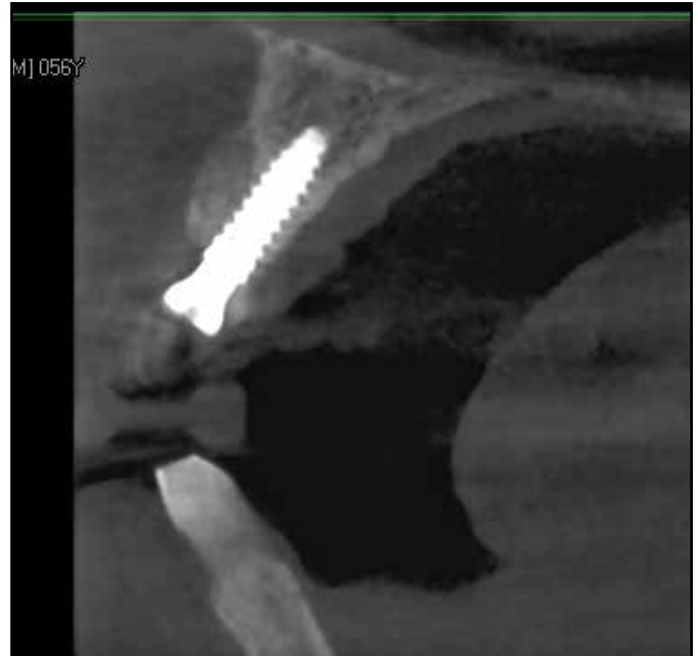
A CBCT as taken at 4 months post graft and implant placement to assess the graft maturation and elimination of the facial socket void.
